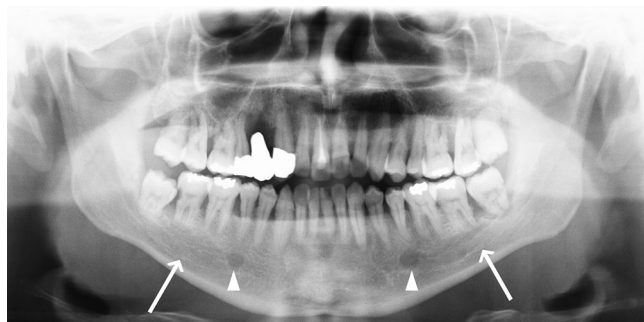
Radiograph of orthopantomography. Enlargement of the mandibular canals (arrows) and the mental foramen (arrowheads) was found on both sides.
